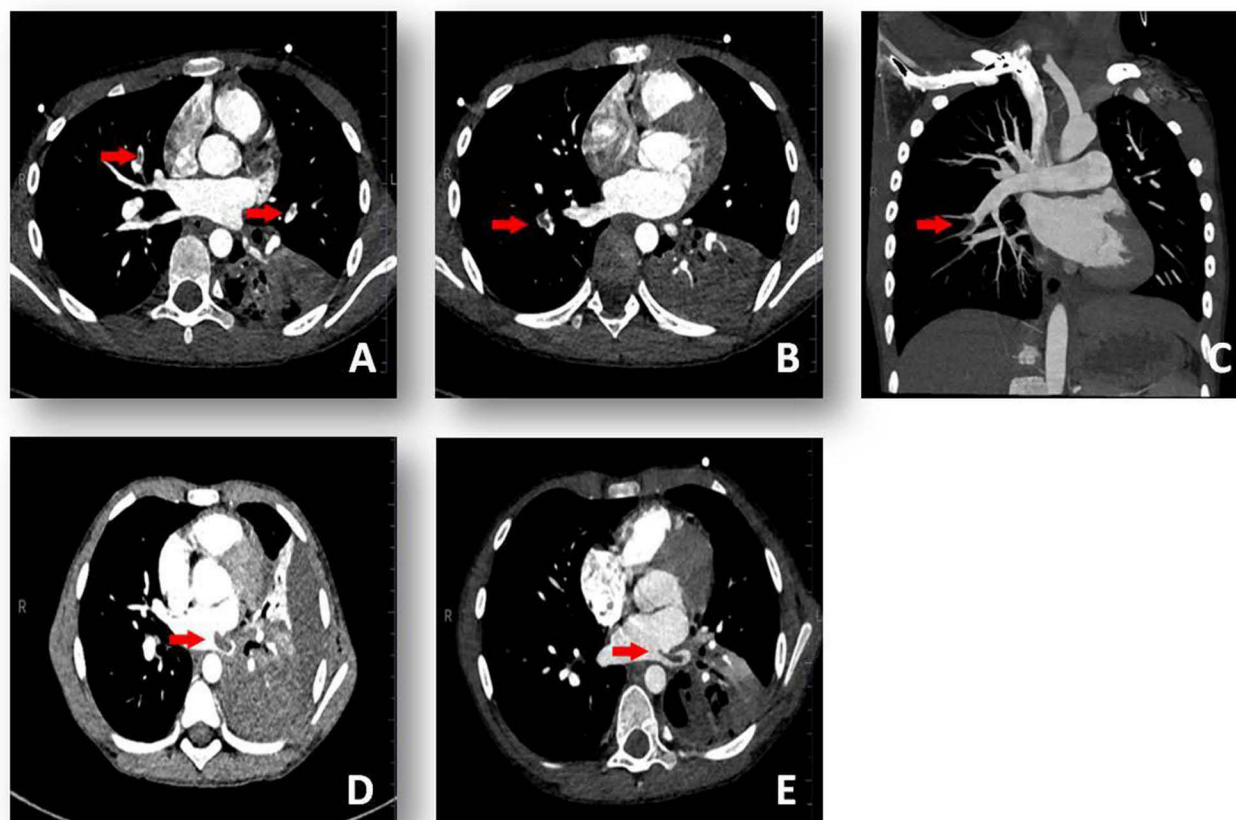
Chest CTA showed a filling defect (red arrow) in the right pulmonary artery and left pulmonary artery (A) Chest CTA showed a filling defect (red arrow) in the right pulmonary artery (B and C). Chest CTA showed a filling defect (red arrow) in the entrance of left atrium and left pulmonary vein (D and E).
